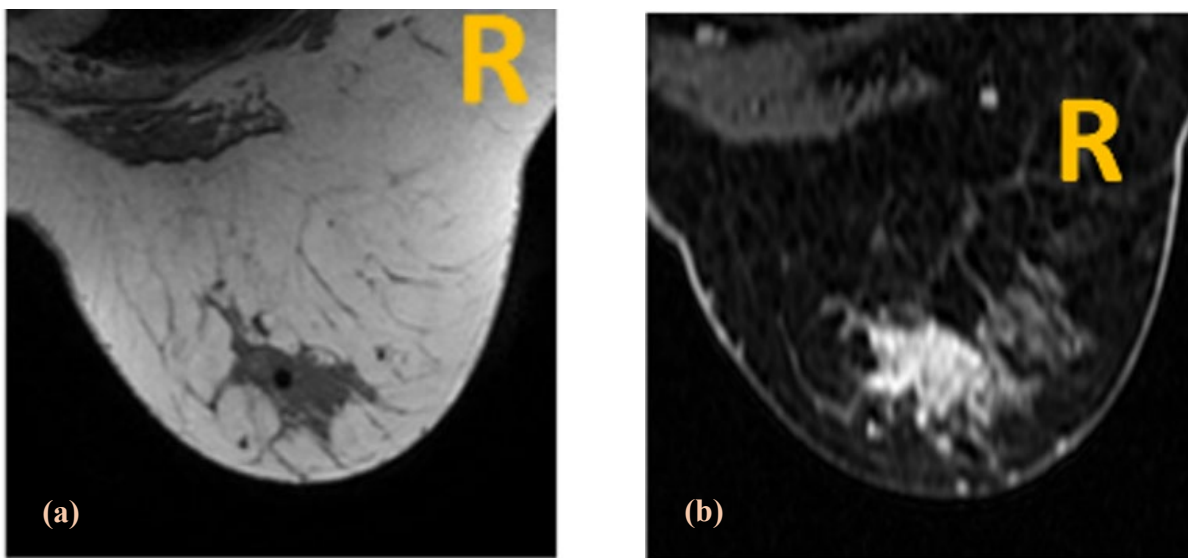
(a) MRI image of the breast prior to fat saturation and (b) fat saturation MRI image of the breast.
